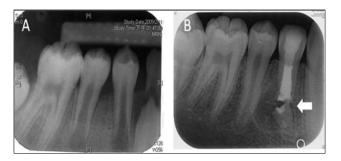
Treatment complication of apexification in a ten-year-old boy, the diagnosis of #44: Pulp necrosis and chronic apical abscess; the presence of apical fistula (A) pre-op radiograph, and (b) the one year and 3-month follow-up of a case treated with Ca(OH) 2 apexification showed the apical fracture.³⁴
